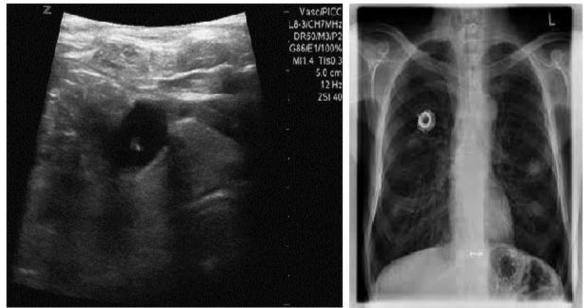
a. Ultrasound image b. X-ray image
